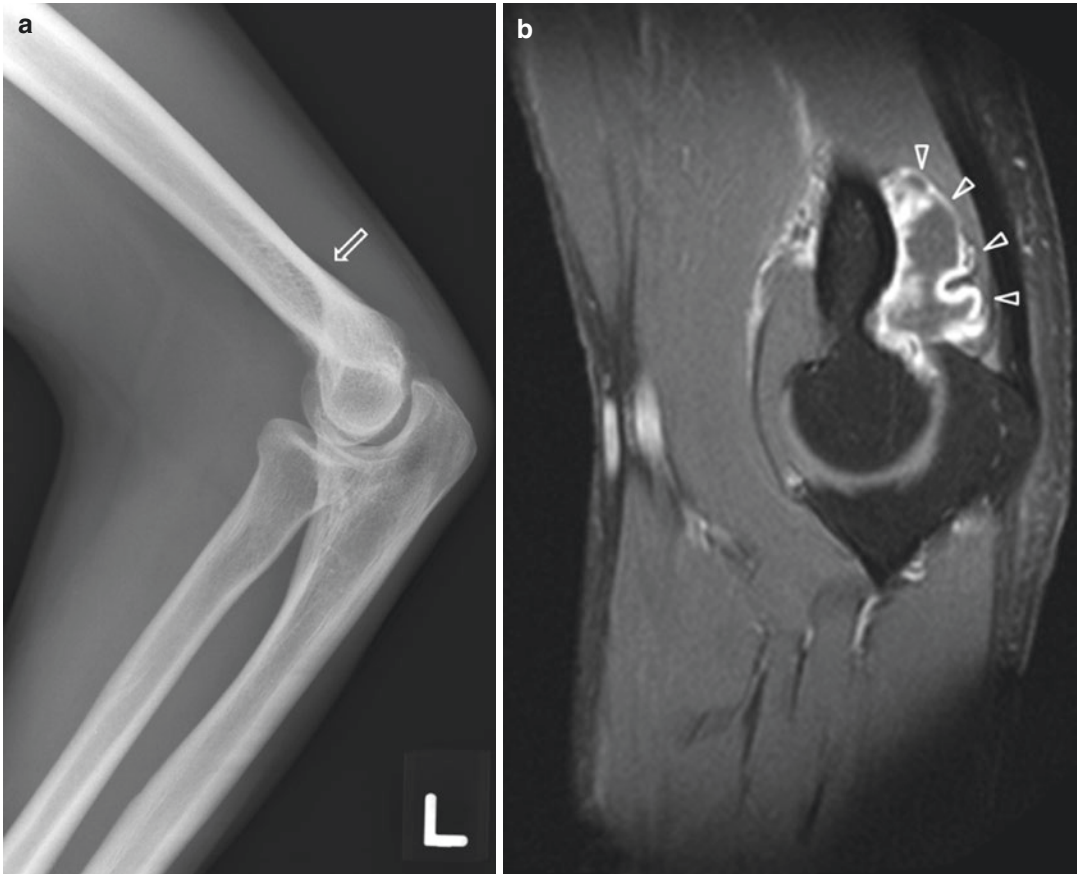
A 36-year-old man who presented with left elbow pain after a traumatic injury. Initial radiographic evaluation of the left elbow was negative for fracture or dislocation. (a) Lateral radiograph shows that the posterior fat pad is just visible (*arrow*), raising suspicion of a joint effusion. (b) Sagittal contrast-enhanced fat-suppressed T1-W MR image of the left elbow confirms
